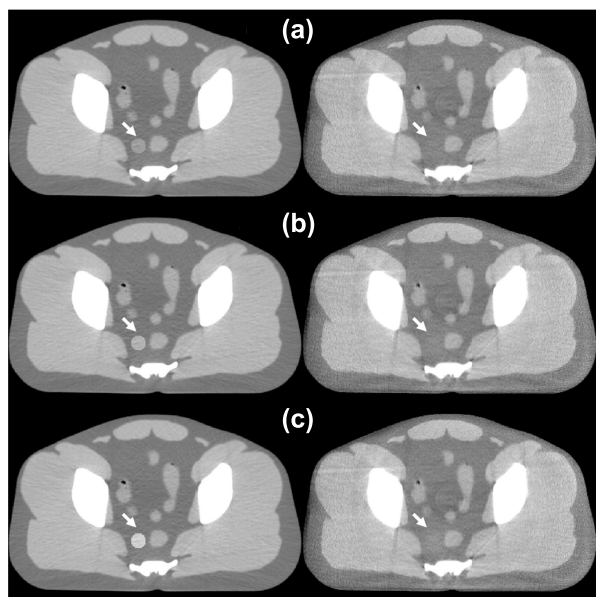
Proposed correction using pCT images with an unmatched insert of different contrasts. Arrows indicate the positions of the contrast insert. Display window: $[-300\ 200]$ HU. Left column: pCT images. Right column: CBCT images after the proposed correction. (a) 50 HU. (b) 100 HU. (c) 150 HU.
